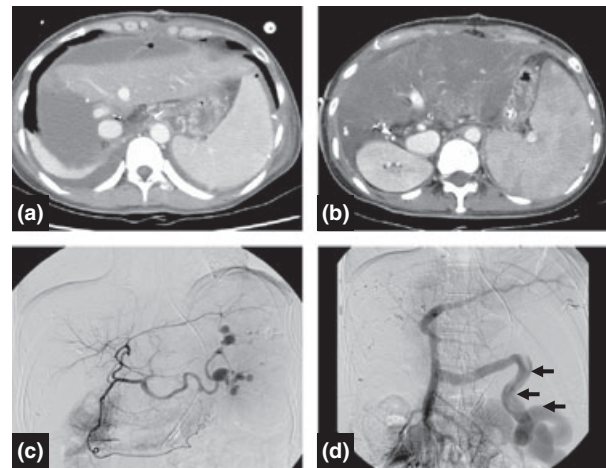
On postoperative day 1, computed tomography (CT) scan showed no specific finding except perihepatic fluid collection (a). On postoperative day 10, CT scan showed total infarction of the graft (b). On the same day, hepatic angiography revealed no thrombosis (c), but large splenomesenteric shunt (black arrows) was noted on indirect portogram (d).
